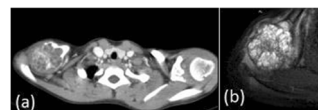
(a) CTscan shows expansion of the bone and thinning of the cortex with multiple loculations. (b) Magnetic resonance image shows multiple septations with multiple fluid levels, but without soft tissues extension
